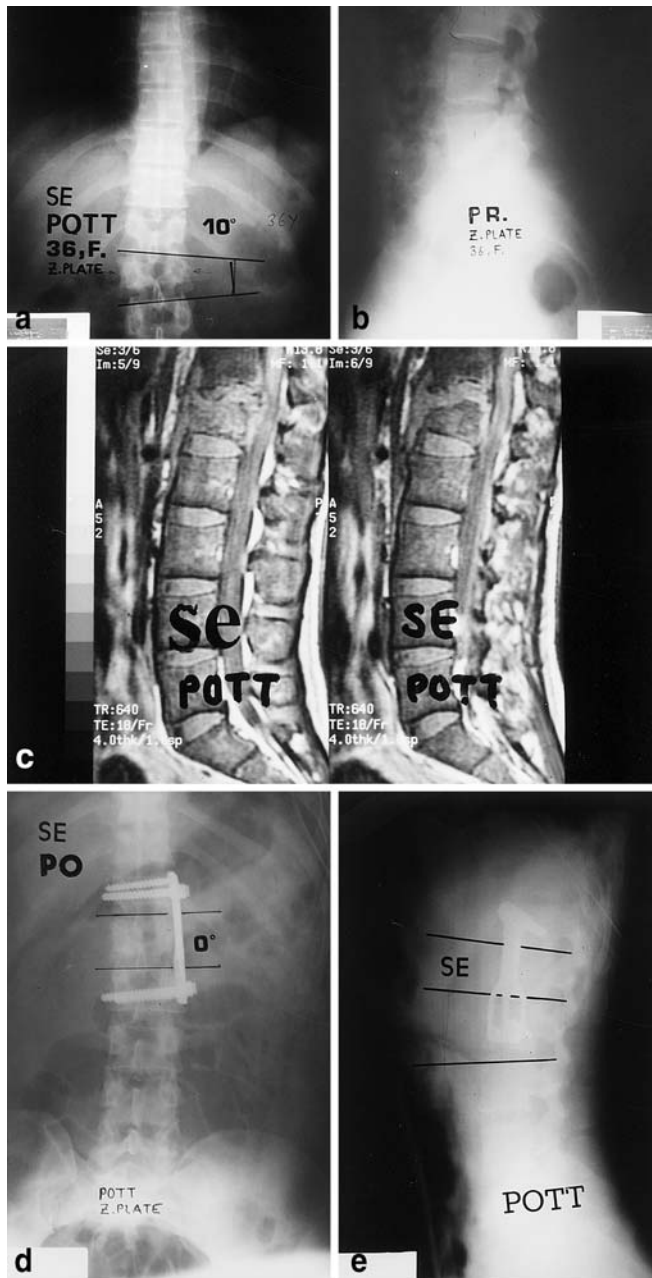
A 36-year-old woman (S.E.) with Pott's disease in the T12–L1 vertebrae. Two mobile segments were instrumented with anterior Z-plate, and a 100% correction rate was obtained after anterior radical debridement and strut grafting and instrumentation in both the frontal and sagittal planes. A Preoperative posteroanterior (A) and lateral (B) graphics, and sagittal MR image (C), and postoperative posteroanterior (D) and lateral (E) radiographs
